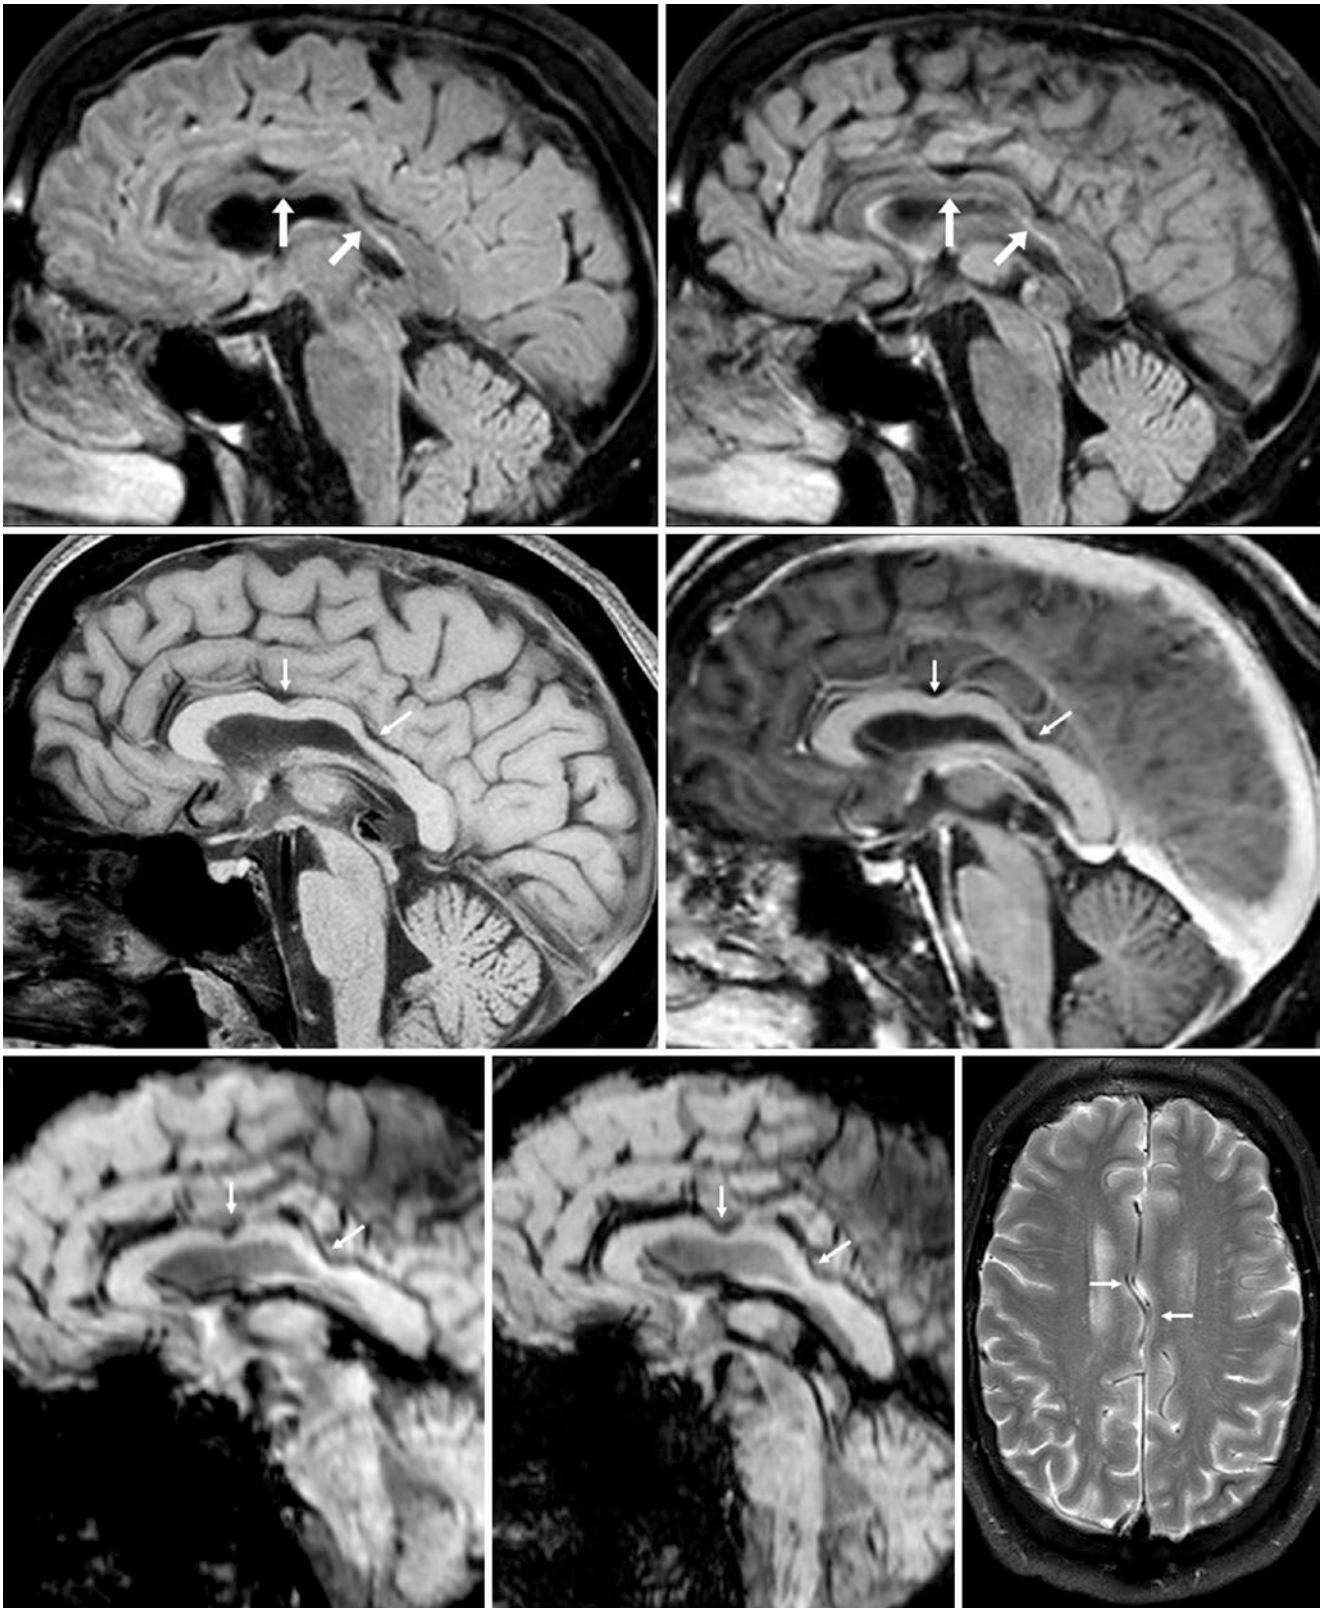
A 54 year old with a 3T MRI performed to evaluate for traumatic lesions. *Top row:* there is normal, moderate indentation of the posterior genu–anterior body of the corpus callosum (*arrows*) on sagittal FLAIR images. *Middle row:* sagittal precontrast (*left*) and postcontrast (*right*) GE T1WI confirm that this impression is related to
